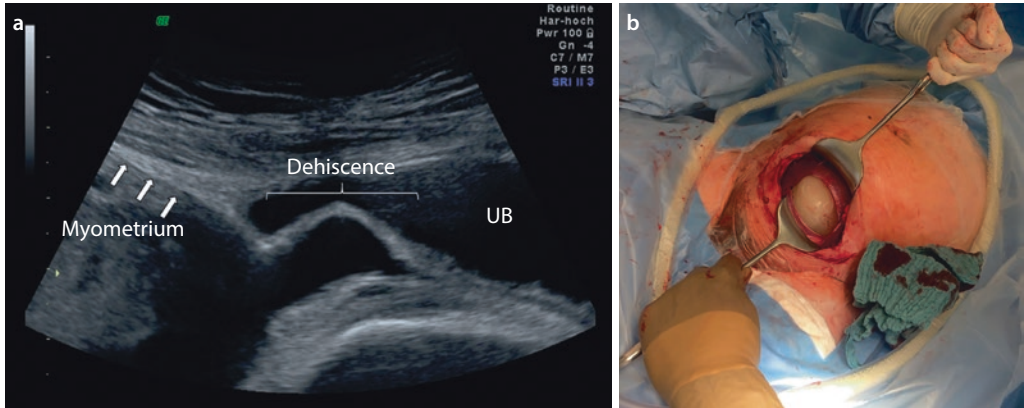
a, b Uterine scar dehiscence. a Transabdominal sonography. b Intraoperative findings. UB Urinary bladder
